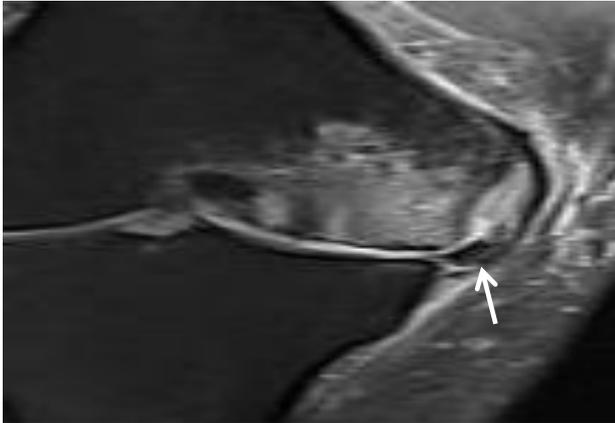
Medial meniscal extrusion. Coronal T2-weighted FSE fat-suppressed image shows extrusion of the meniscal body (arrow) secondary to an underlying meniscal tear.
